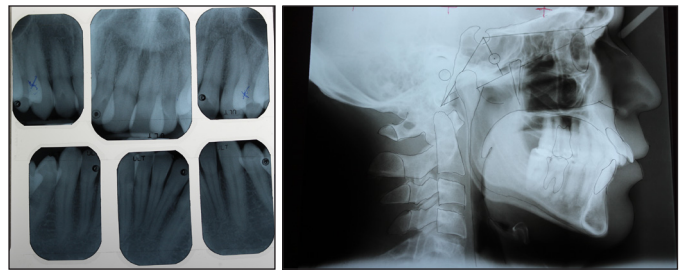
A) Pre-treatment PA radiograms; B) Pre-treatment panoramic radiogram; C) Pre-treatment lateral cephalometric radiogram; D) Pre-treatment cephalometric tracing
